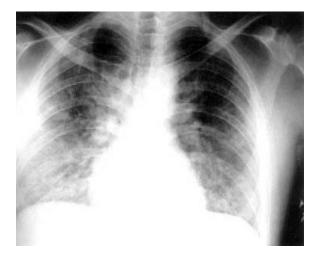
Chest roentgenogram of patient with *P. carinii* pneumonia, demonstrating diffuse infiltrates.
